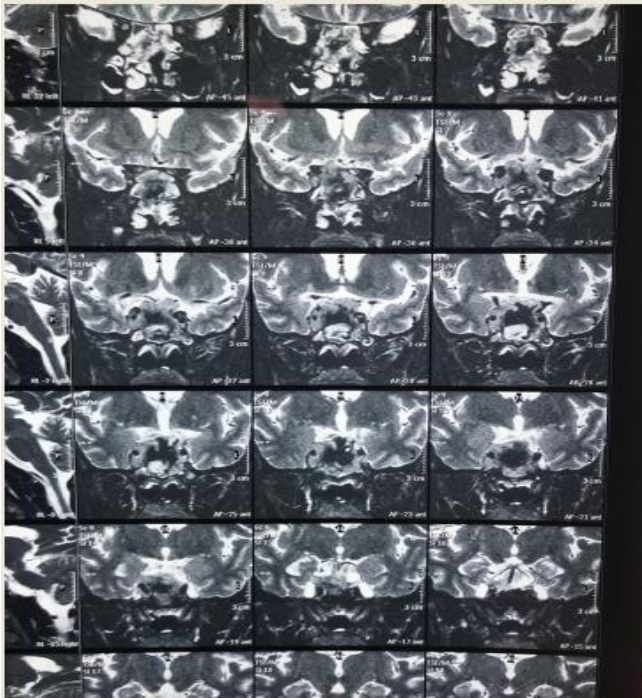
Postoperative MRI following excision of pituitary adenoma
